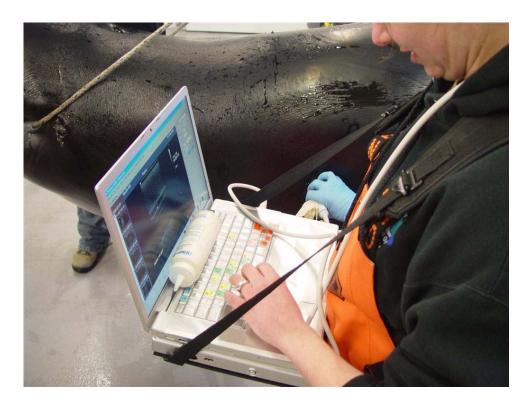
Terrason 3000 ultrasound system deployed on a single stranded pilot whale.
